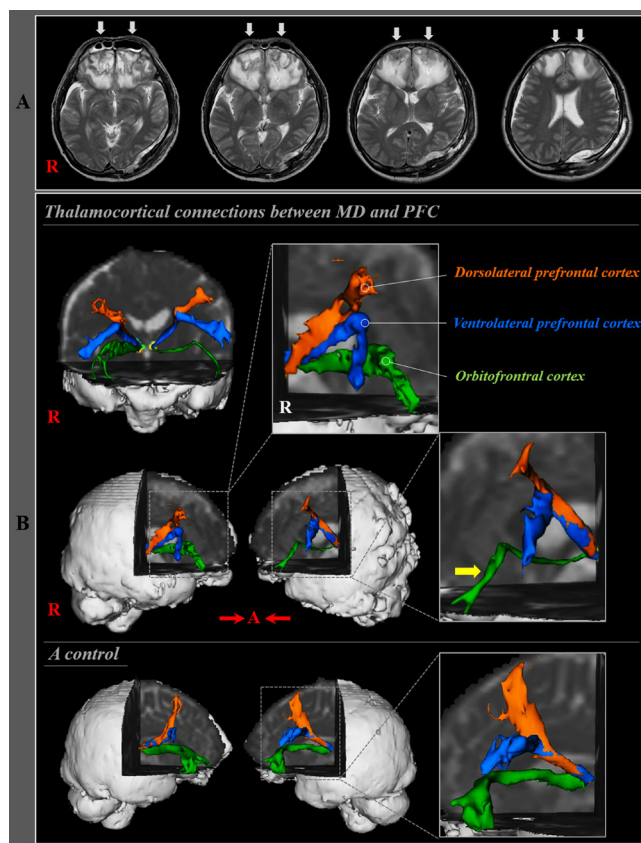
MRI and diffusion tensor tractography images of a 55-year-old male patient with traumatic brain injury and a control subject. (A) Brain MRI at two weeks after onset shows severe injury (arrows) on both prefrontal cortices. (B) Results of diffusion tensor tractography of the thalamocortical connections to each prefrontal cortex region in the patient and a control subject. The integrities of the thalamocortical connections to the ventrolateral and dorsolateral prefrontal cortex were preserved, however, the thalamocortical connection to the orbitofrontal cortex shows that the patient's left side is thinner than the right side and that of the control subject (arrow).
